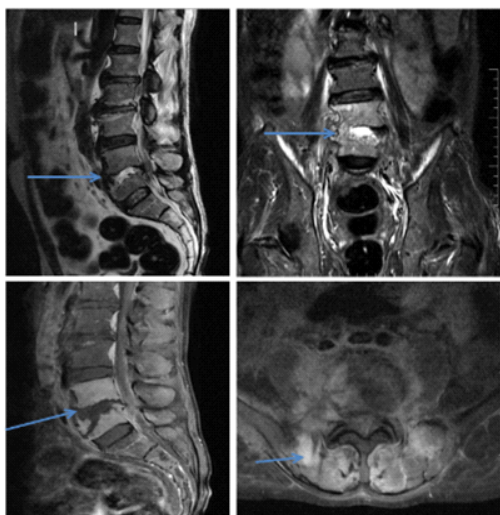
60 year old elderly male presented with low back ache, radiating to both lower limbs since 5 months. A) Sag T2WI B) Coronal STIR MR images shows, T2 hyperintense collection seen in L4/L5 intervertebral disc space with irregularity and destruction of adjacent vertebral end plates. There is irregular destruction of L5 vertebral body with reduction in height.
